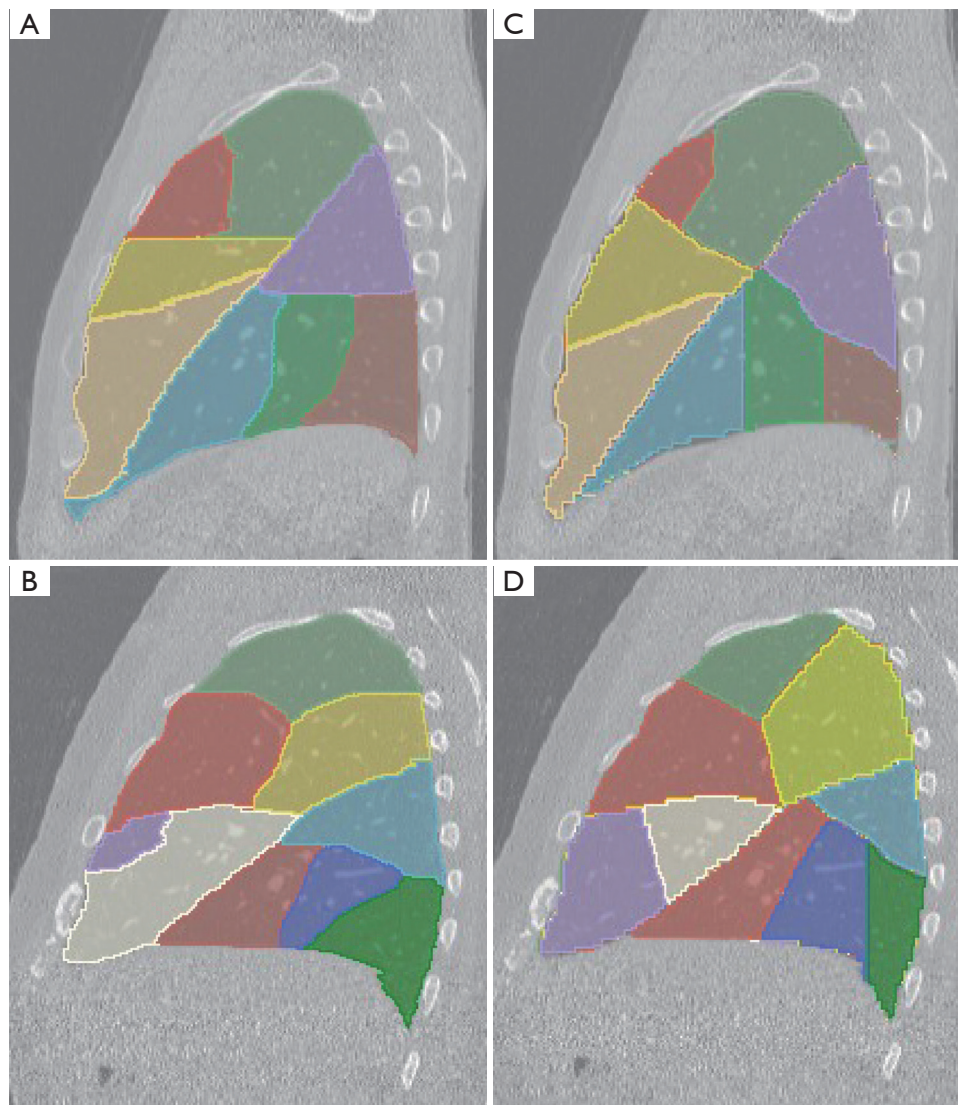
The comparisons of the segmentation for two selected scans (the rows), presented in the sagittal view to display as many segments on each slice as possible. The first row depicts the left lung, while the second row depicts the right lung. (A,B) The CT images with manual segmentation. (C,D) The CT images with BT-based segmentation. The choice of slices ensures that a maximum number of pulmonary segments are visible in each image. CT, computed tomography; BT, bronchial tree.
